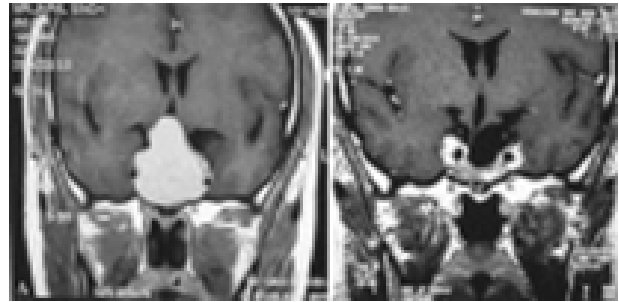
Pre op. MRI (a) and Post op. MRI (b) after 6 months
